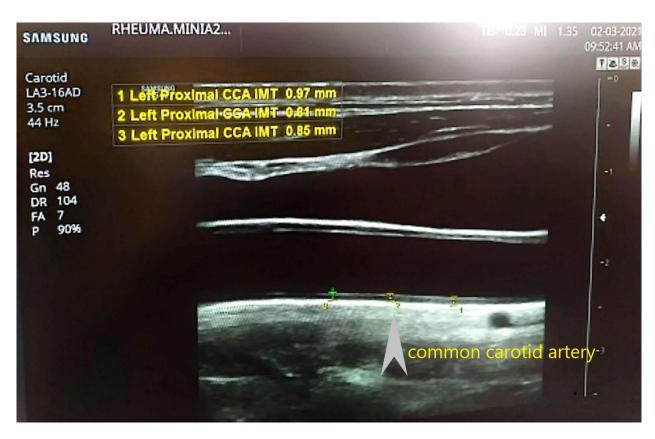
This figure demonstrates ultrasonography of the left common carotid artery just below the common carotid bifurcation (CCB) level. This is a psoriatic arthritis patient in a supine position with the head slightly extended and laterally rotated then Longitudinal images of the carotid arteries are obtained in which the leading edges of the lumen-media and adventitia interfaces (the double-line pattern) of the arterial wall represent intimal-medial thickness which was increased
